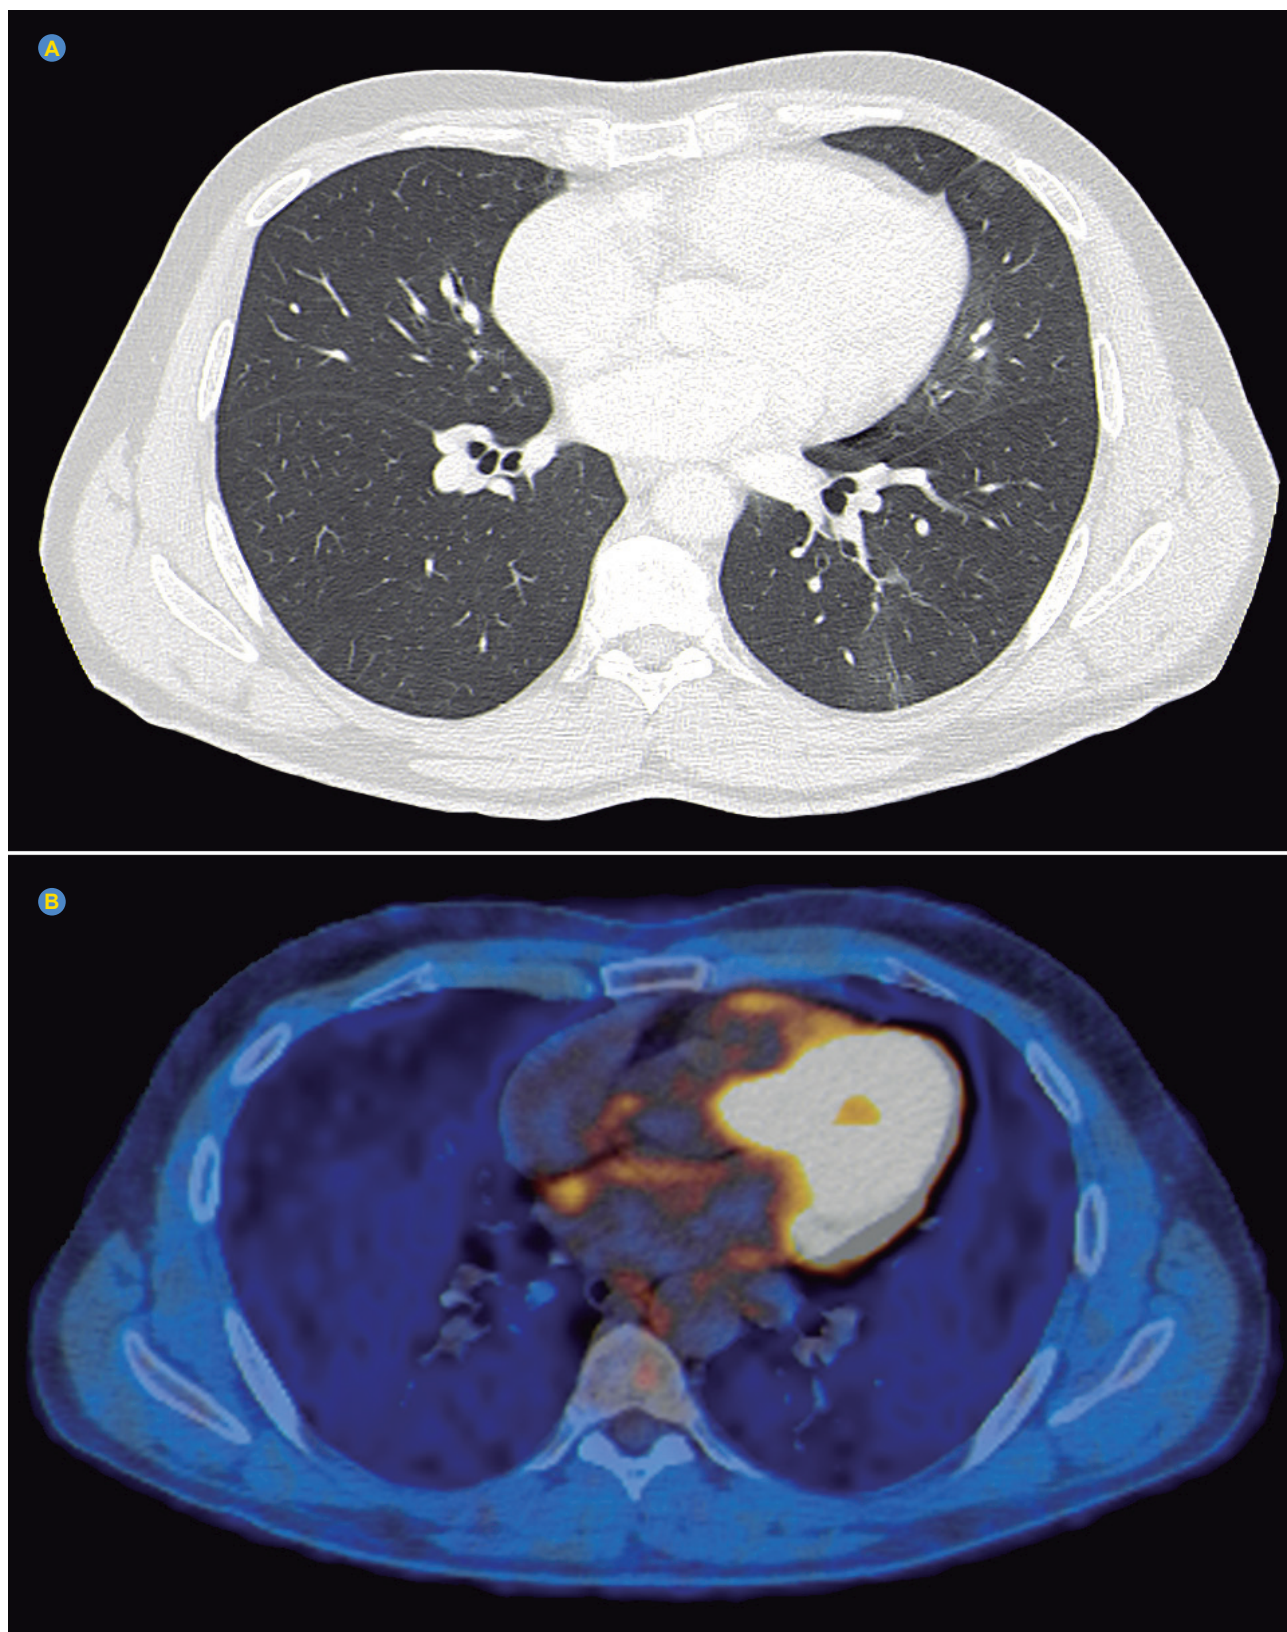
Chest CT (A) and PET scan (B) showing complete metabolic response on the chest
